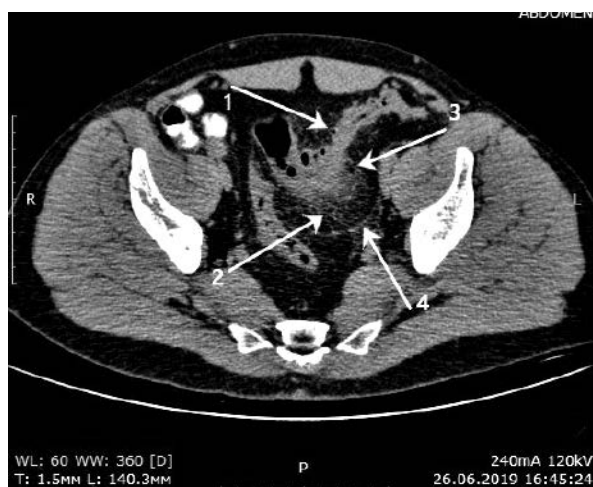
CT of patient B., 64 years old. Diverticular disease of the sigmoid colon complicated by diverticulitis. Multiple diverticula of the sigmoid colon (arrow 1). Stranding of paracolic fat (arrow 2). Gas outside the intestinal lumen (arrow 3). Thickening of the mesenteric root of the sigmoid colon and f. retrocolica (arrow 4).
